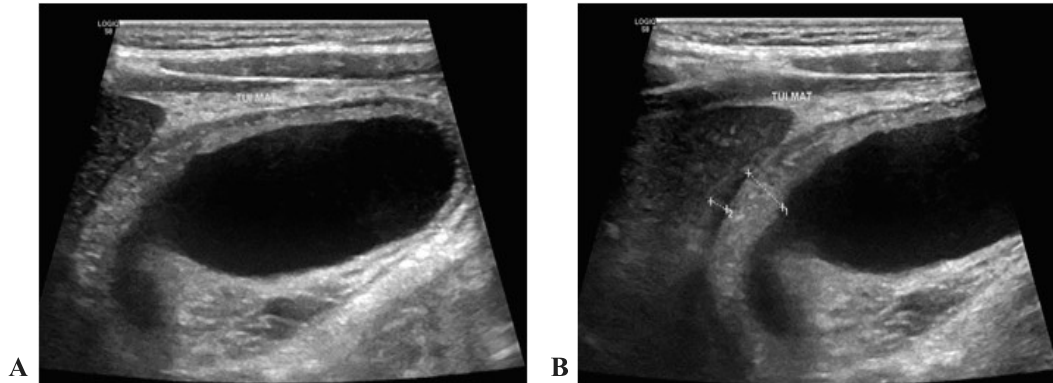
A. Ultrasonography showing a large wall thickening gallbladder without stones.
